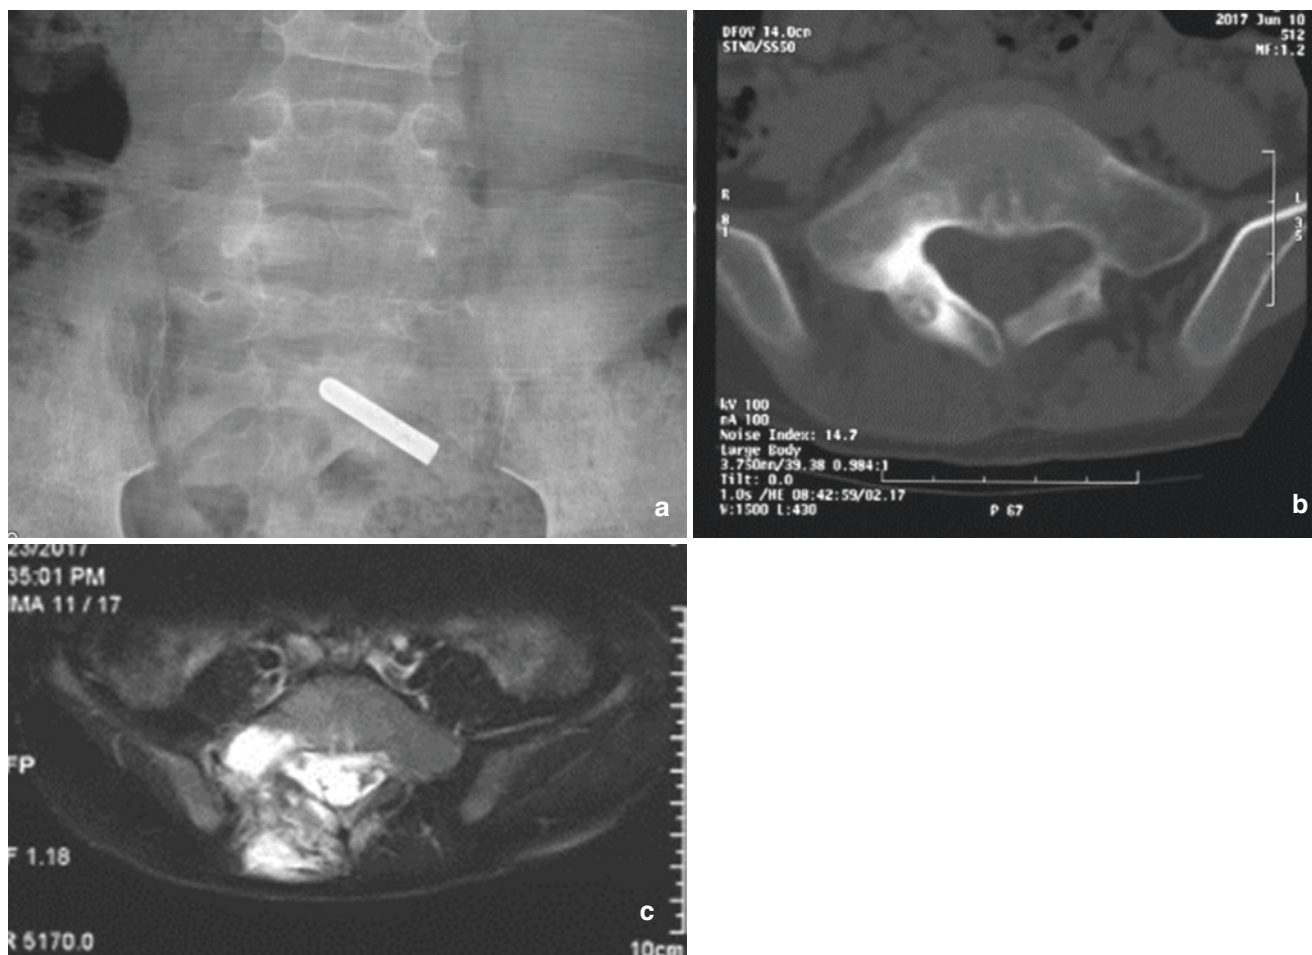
Radiological studies obtained in a 7-year-old man with osteoblastoma. (a) Anteroposterior radiograph revealing a subtly osteogenic lesion at S1 (arrows). (b and c) Axial CT and MRI scan demonstrating bone matrix within the minimally expanded lesion, not
